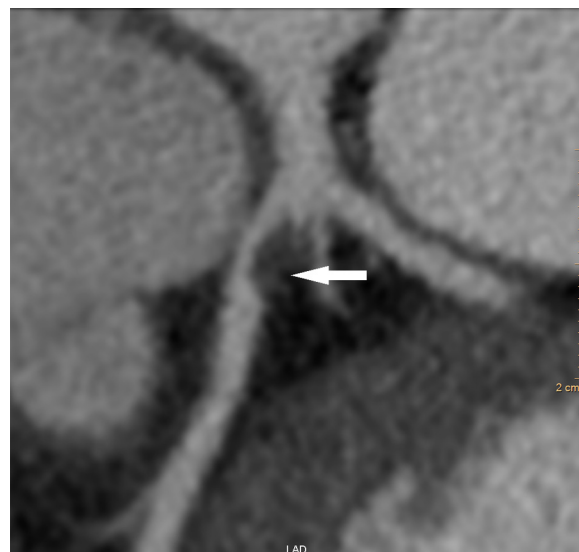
Large noncalcified plaque in the proximal left anterior descending coronary artery is shown on coronary CT angiography.
